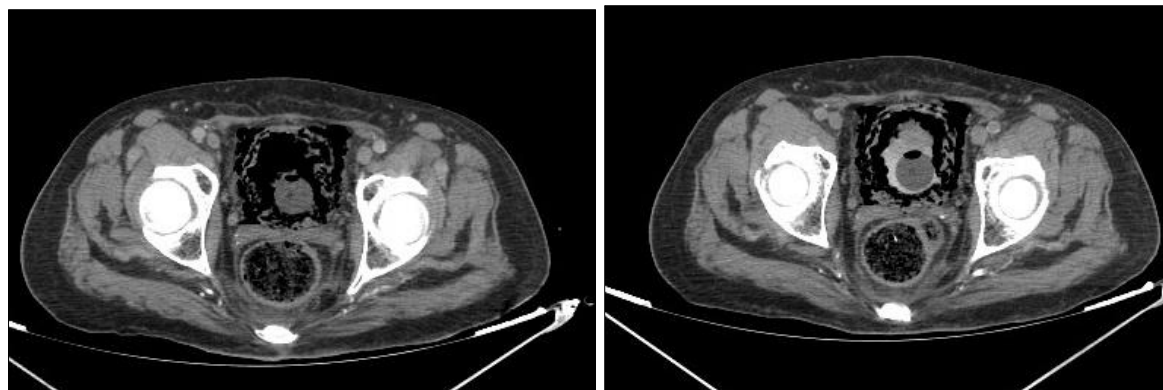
CT scan revealed thickening of the bladder wall, with intramural and intraluminal gas bubbles and opacification of the perivesicular fat
